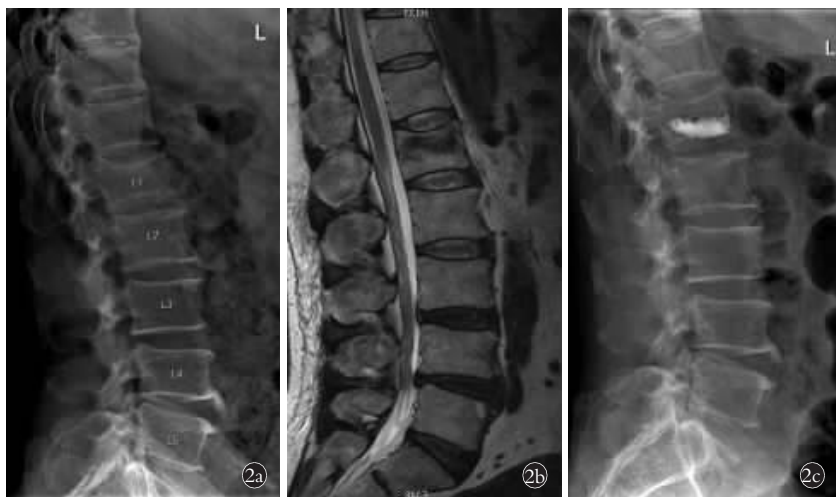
患者,男,66 岁,跌倒致腰部疼痛 2 d 住院 2a. 术前侧位 X 线示 L<sub>1</sub> 椎体压缩性骨折 2b. 术前 MRI 示骨折线位于椎体中上部 2c. 术后 X 线显示骨水泥位置偏下,通过计算发现骨水泥在骨折线区域分布范围<50%,纳入对照组
